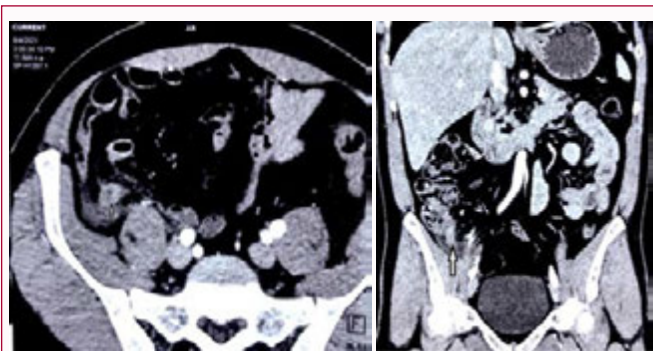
Contrast-enhanced axial and coronal CT of abdomen shows wall enhancing enlarged Appendiceal stump (arrow) with fat stranding.
